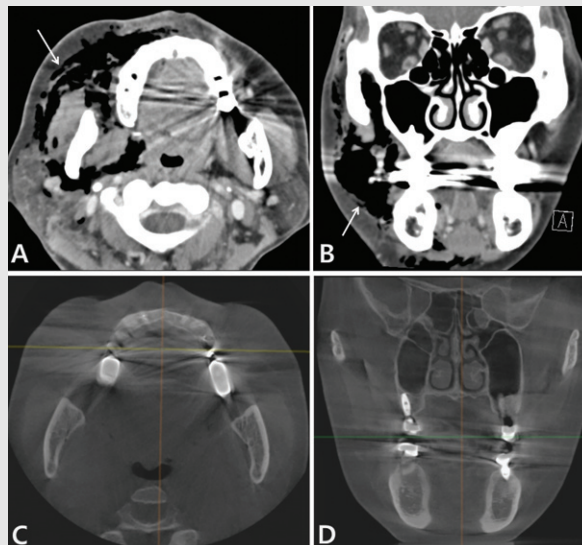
Radiographs taken during the initial examination and 17 days later. A) Diffuse soft-tissue infiltration with air densities (arrow) in the right periorbital, buccal, submandibular, parapharyngeal, and retropharyngeal spaces on facial bone computed tomography (CT) (axial view); B) facial bone CT (coronal view); C) all air densities have disappeared on cone-beam computed tomography (CBCT) (axial view); D) all air densities have disappeared on CBCT (coronal view)
